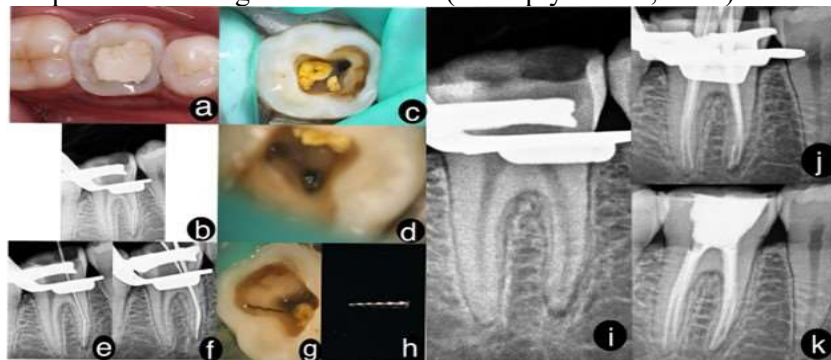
a) Pre operative clinical b) Pre operative radiograph c) Covering other orifices with teflon d) Straight line access e) Bypassing first file from inner curvature f) Bypassing BI from other 2 sides g) file popped out in access cavity h) retrieved file i) Post retrieval radiograph j) Master cone radiograph k) Obturation radiograph
